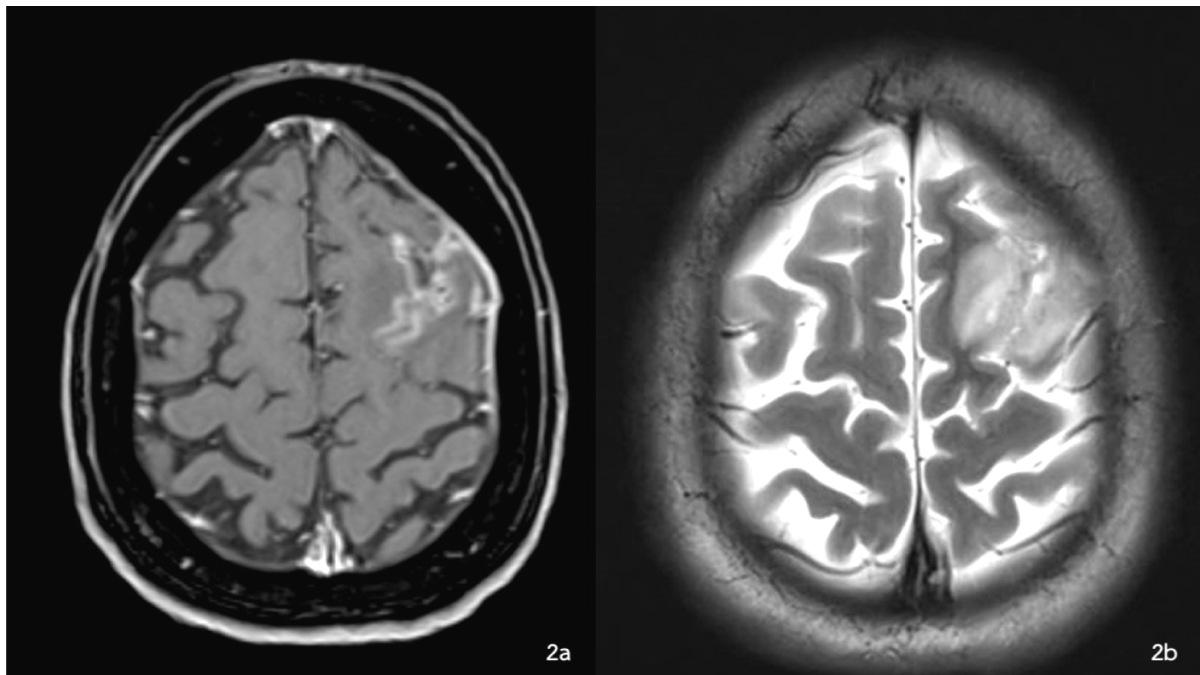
a: and b: Axial contrast-enhanced T1-weighted MR image and T2-weighted MR image shows an irregular contrast enhancing lesion involving left high frontal lobe and adjacent cortical sulci, associated with vasogenic edema of adjacent brain
